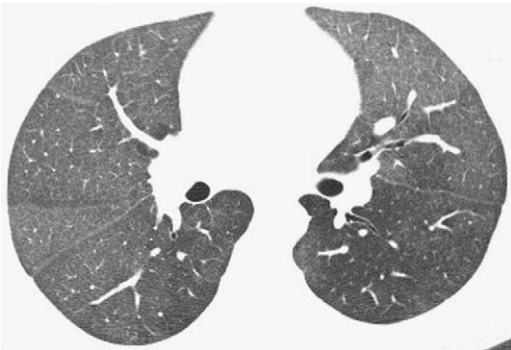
Ground-glass opacity on HRCT imaging: pulmonary hemorrhage. Axial HRCT image shows multifocal bilateral ground-glass opacity, best appreciated in the right lung, in a patient with hemoptysis and systemic lupus erythematosus.
